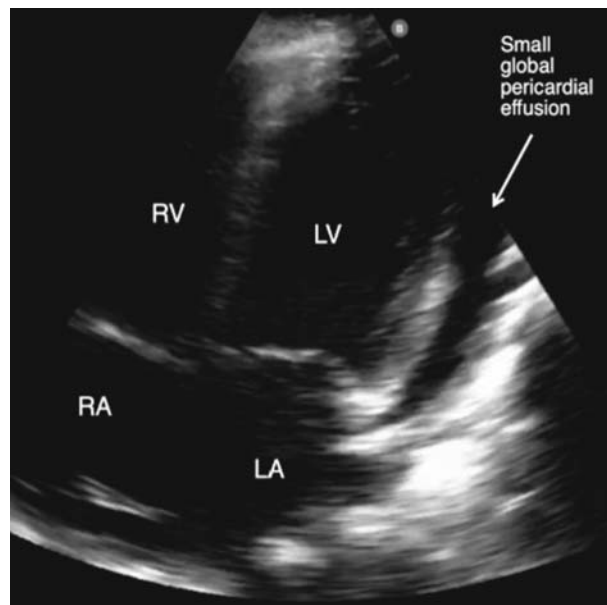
Apical four chamber view of a two dimensional echocardiogram of the patient showing a small global pericardial effusion. LA-Left Atrium; LV-Left ventricle; RA-Right atrium; RV-Right ventricle.
